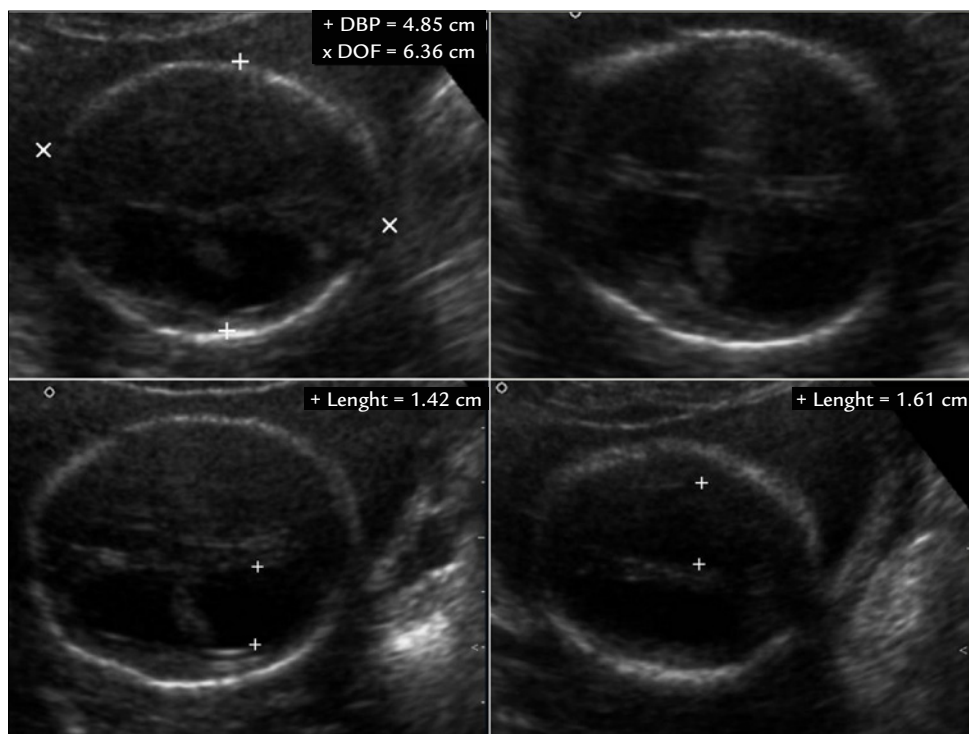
Obstetric ultrasonography showing the fetal cephalic pole with enlarged lateral ventricles, and biparietal and occipitofrontal diameters within the expected range.
